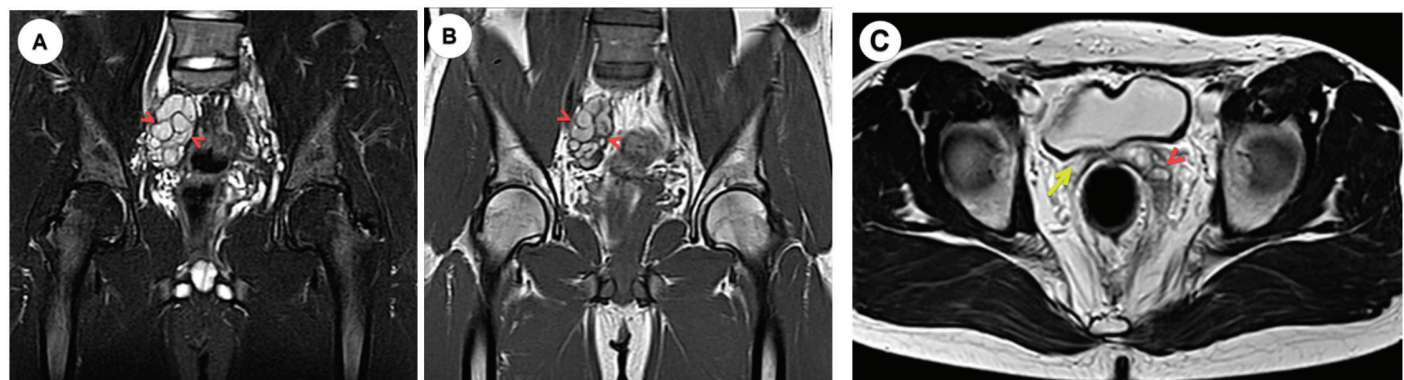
a) T2-weighted and b) T1-weighted coronal magnetic resonance (MR) images of the pelvis show the hyperintense pelvic lesion on both sequences is consistent with a proteinaceous/hemorrhagic cyst (arrowheads). c) T1-weighted axial MR image at the level of prostate demonstrates the normal left seminal vesicle (arrowhead) and the absence of the right seminal vesicle (arrow). The right pelvic mass is consistent with ectopic and a dilated right seminal vesicle, according to pelvic MR imaging findings
